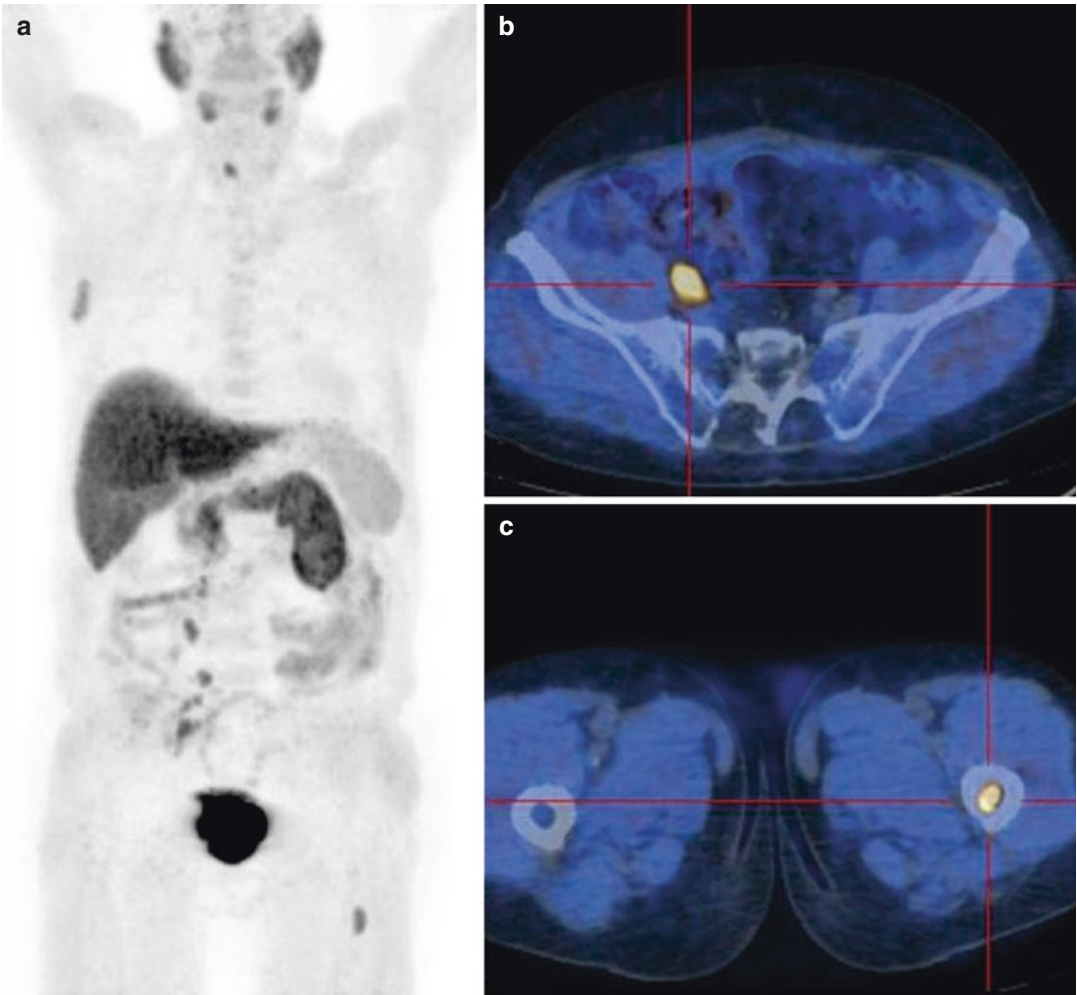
A patient was submitted to radical prostatectomy for prostate cancer Gleason 8 (5 + 3). Subsequently, radiotherapy on the prostatic bed was also administered due to early biochemical relapse. At the time of the ^{18}F -FMC PET/CT scan, PSA was rapidly rising (PSA 16 ng/mL; PSA $_{dt}$ 4 months; PSA $_{ve}$ 1.5 ng/mL/year). The PET
